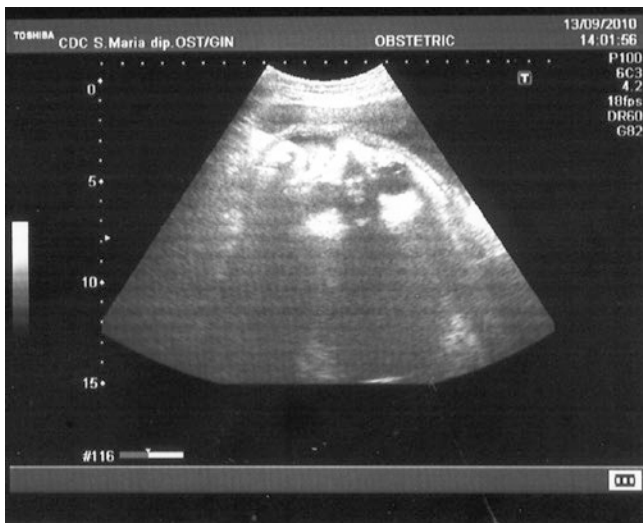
Transabdominal transversal sonographic scan of the fetal head in left occiput posterior position during the second labor stage in epidural analgesia. The picture shows the fetal orbits, the lens, the nasal bridge, and the occipital bone in the left pelvis
